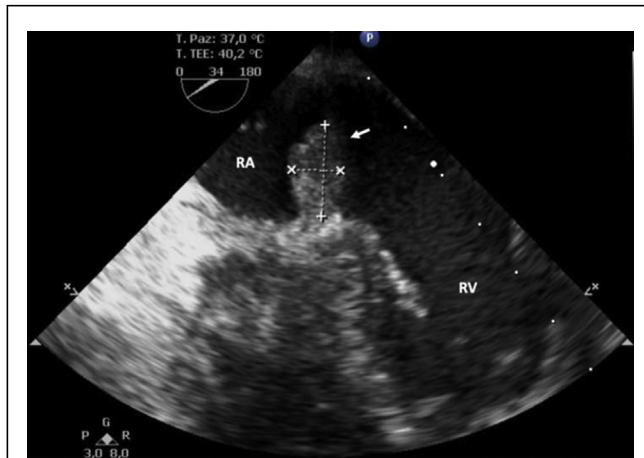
Transesophageal echocardiography in the deep trans-gastric view shows oscillating multiple hyperechogenic vegetations attached to the tricuspid bioprosthesis, the largest measuring 15 × 8 mm (arrow). (RA, right atrium; RV, right ventricle.)
